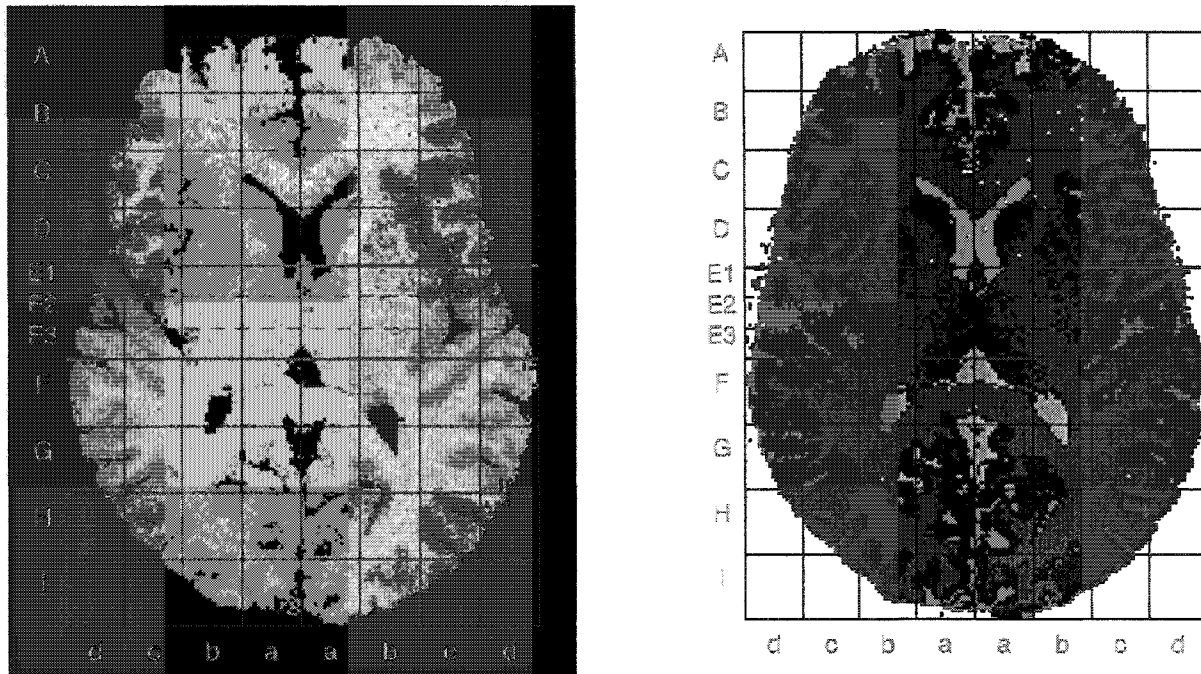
Axial view of a Talairach grid built upon an MRI and its corresponding description by the Talairach atlas. Definition of ROIs can be easily made by following the atlas<sup>9</sup>. ROIs are defined as series of cells encompassing each brain region. Large brain regions, like the frontal lobe, are better defined than small structures like the caudate or the thalamus.
